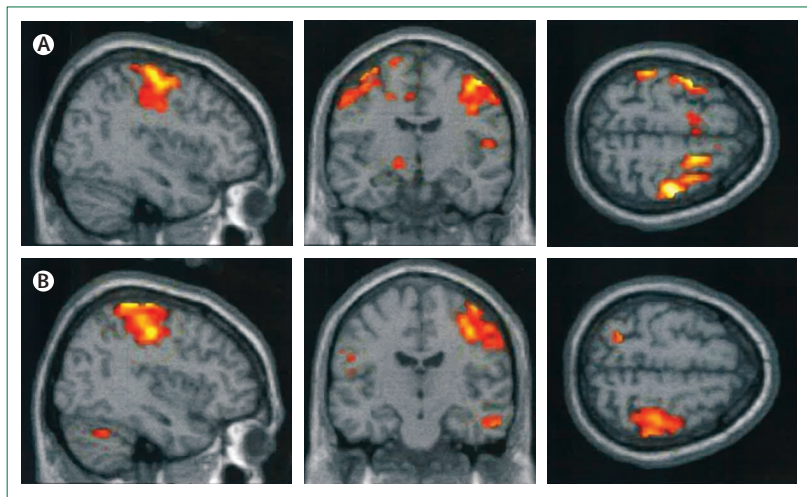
Functional MRI scans show abnormal activation in the brain
